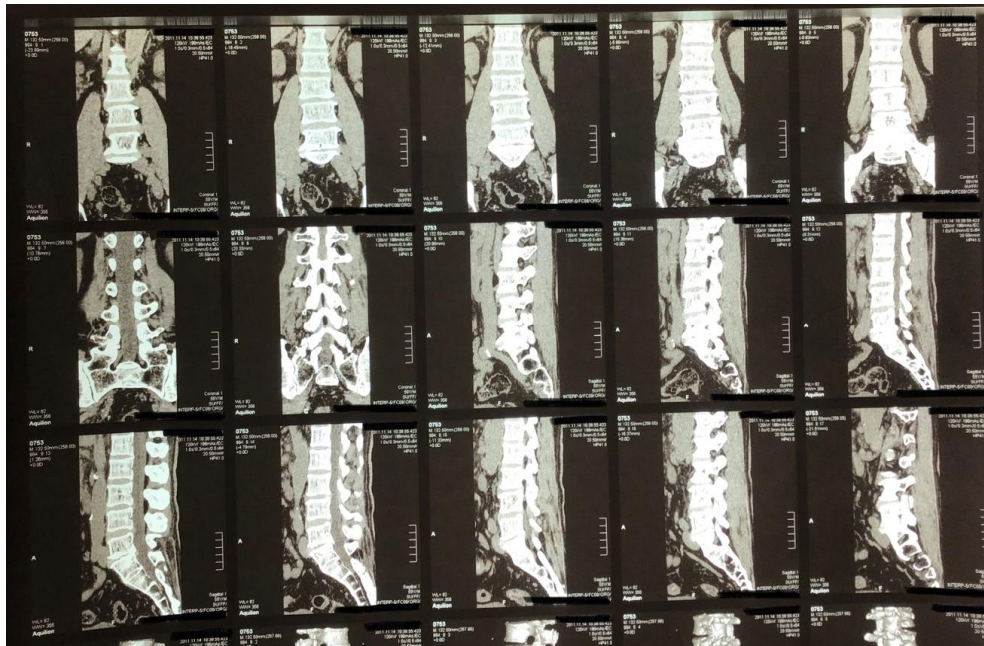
Post-operative follow up 11 years Lumbar CT scan
